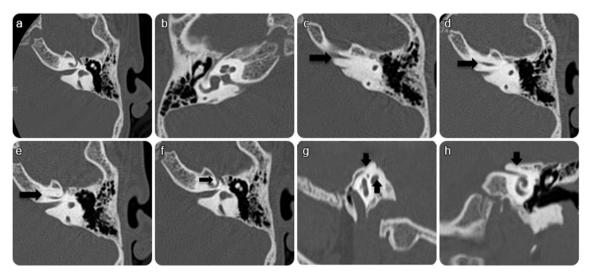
A, B; High-resolution axial CT scan images of the temporal bone demonstrate asymmetrical narrowing of both internal auditory canals, the right more than the left
